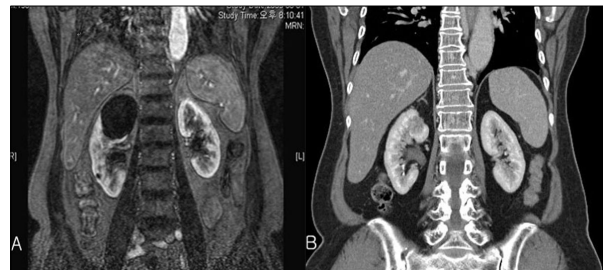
Imaging of a 47-year-old woman with flank pain. (A) Coronal MRI shows a simple right renal cyst with diameter of 5.8 cm. (B) 3 months after percutaneous sclerotherapy with OK-432, CT image shows no remnant of cyst.
